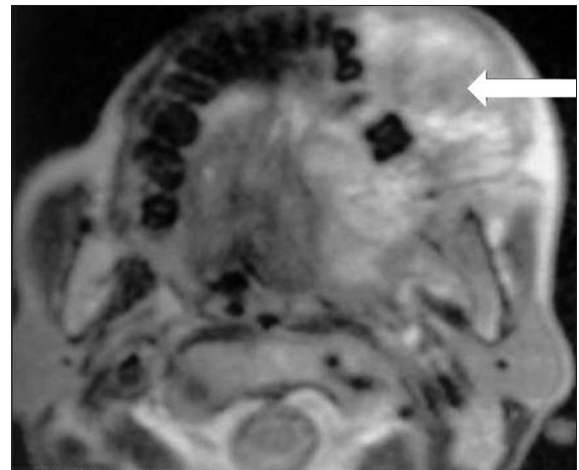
72-year-old female with swelling on the right side of her mandible diagnosed as carcinoma of the mandible. Axial T1-weighted MRI shows mixed intensity lesion involving mainly the left hemimandible (arrow).
